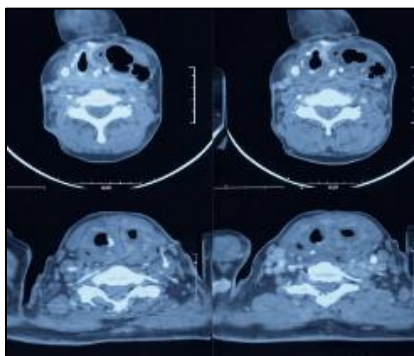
Axial contrast-enhanced cervical CT scan showing a left laterocervical abscess extending into the retropharyngeal space
